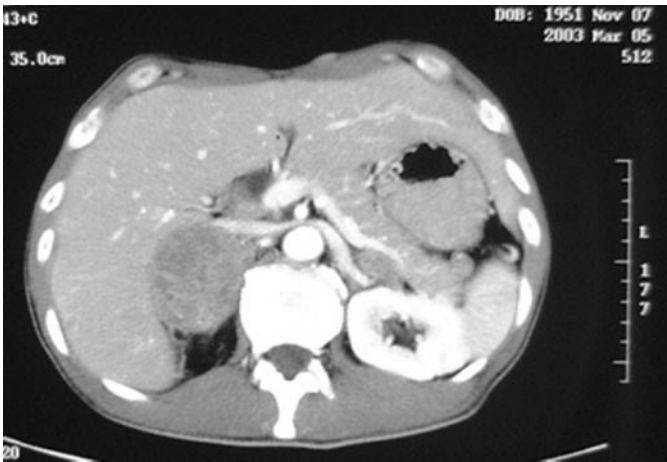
Abdominal computed tomography disclosed adrenal metastasis 2 months after completing initial treatment (February 2003).
